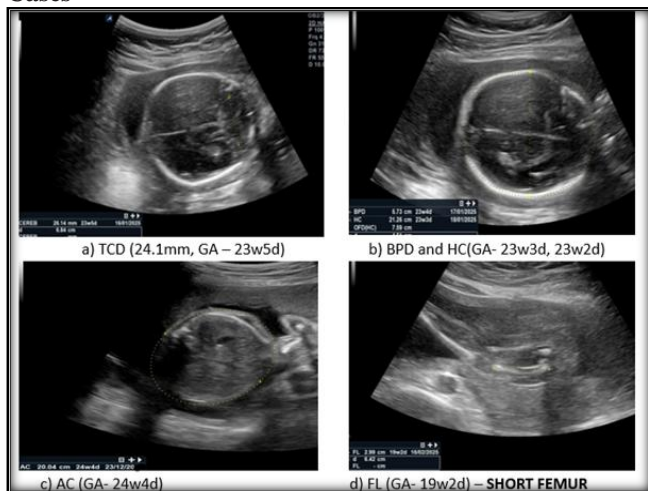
Estimated gestational age by Ultrasound fetal parameters (Hadlock formula) in a primigravida with fetal skeletal dysplasia.
